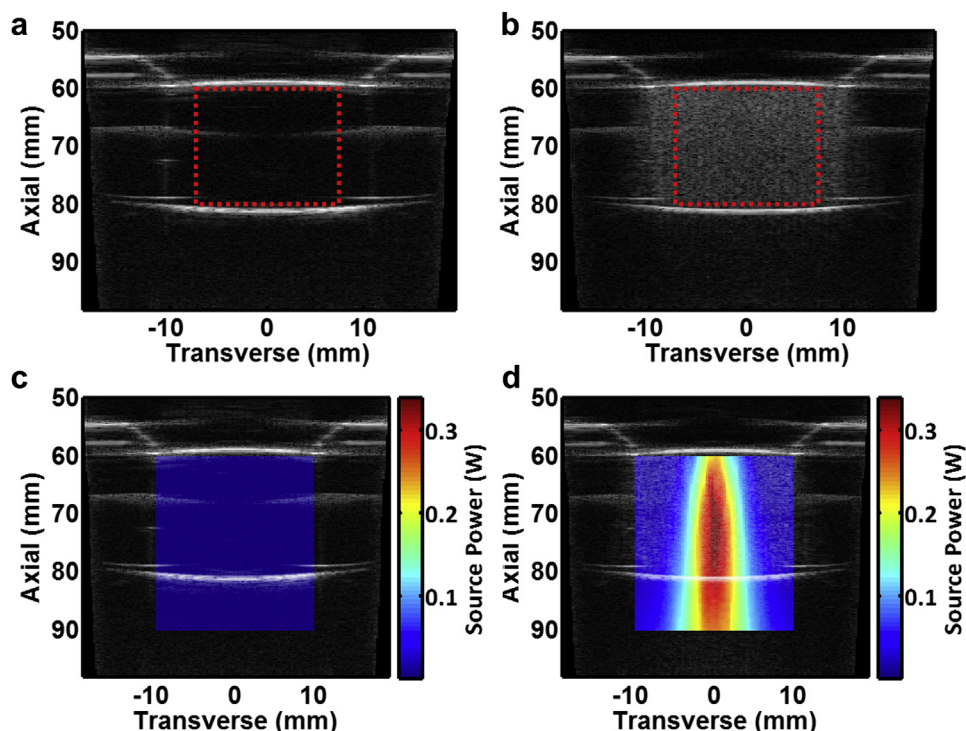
(a, b) *In vitro* acoustic testing of magnetic microbubbles under B-mode imaging. A region of interest (ROI) within the sample holder is represented by the red dotted box. B-Mode images for the sample holder containing (a) water and (b) 10% by volume magnetic microbubbles (MMBs). (c, d) *In vitro* acoustic testing of magnetic microbubbles under focused ultrasound excitation. B-Mode images with passive acoustic mapping (PAM) overlay showing maps of source power for (c) water and (d) 10% by volume MMBs.
